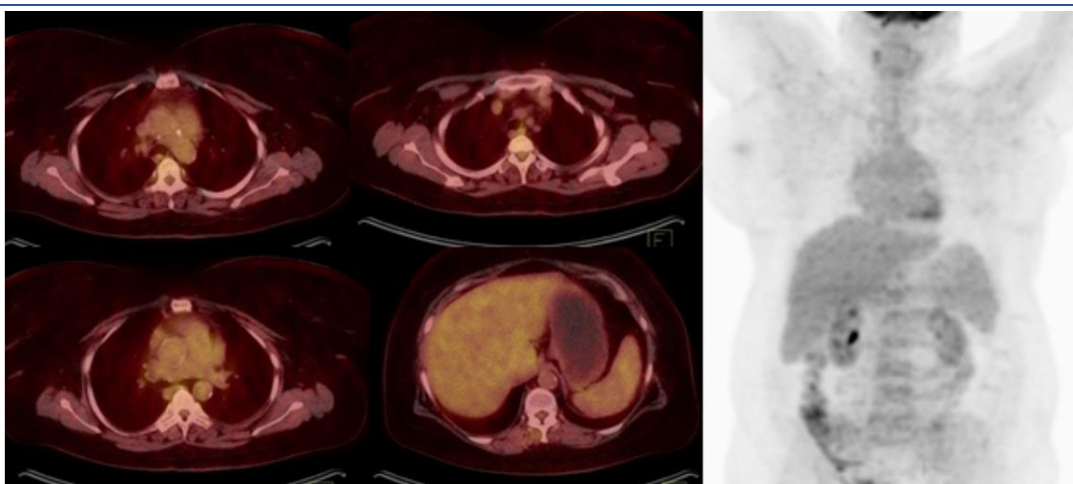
Positive scan result (grade 3 2-[<sup>18</sup>F]FDG uptake in the left carotid artery, innominate artery, and thoracic aorta (compared with liver background activity) in PET-CT fused images) in a person with active TA according to the NIH criteria treated with high-dose immunosuppressive drugs. A 40-year-old woman known case of TA from the age of 32 with a history of aortic valve replacement was treated with 50 mg of prednisolone daily and 30 mg of methotrexate weekly
